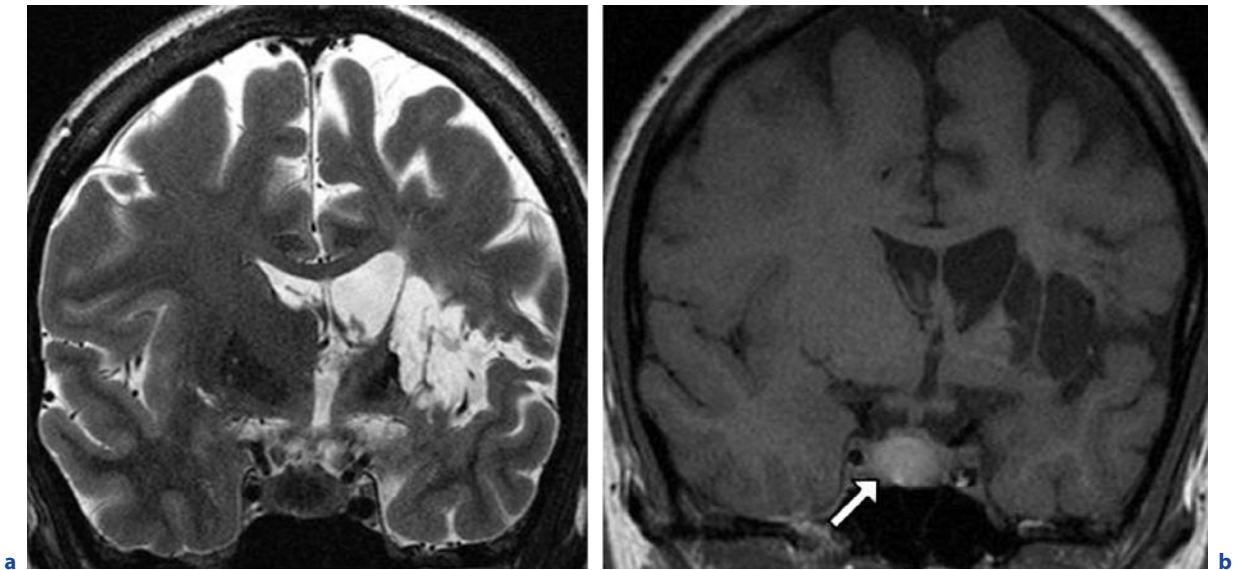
Drug-induced vasculitis. A 22-year-old woman with chronic cocaine abuse. a Coronal T2-weighted image. b Coronal T1-weighted image. Parenchymal defects of the left basal ganglia and evacuo-enlargement of the ipsilateral ventricles subsequent to an infarct in the territory of the left MCA
